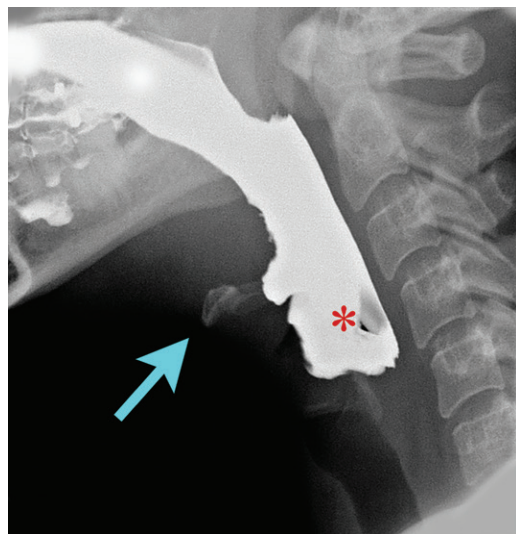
Delayed initiation of the pharyngeal swallow in a 55-year-old man. Lateral radiograph shows the bolus in the oropharynx and hypopharynx (*), with the hyoid bone still in resting position (arrow) due to a delayed triggering of the swallowing reflex.
